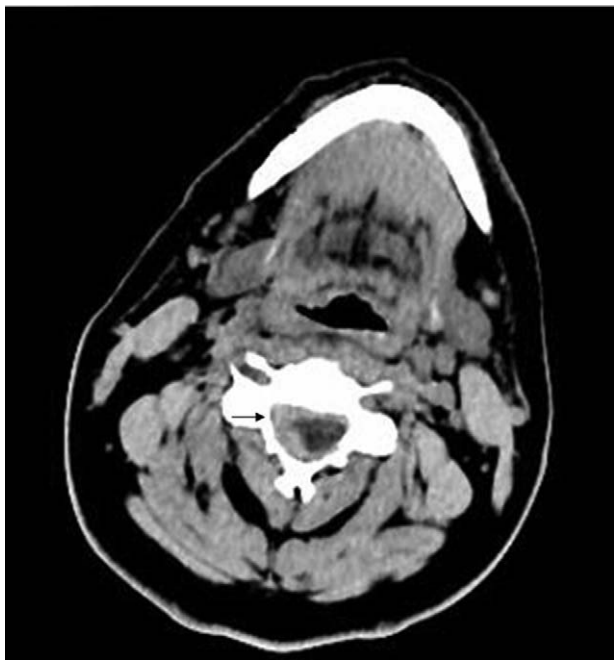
Axial computerized tomography (CT) showing epidural high-signal density to C4.
